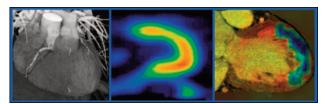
Multislice spiral CT angiography (left) revealed structural lesions when myocardial sestamibi SPECT (middle) showed no abnormalities. The 2 techniques can be combined (right) to yield additional information.
